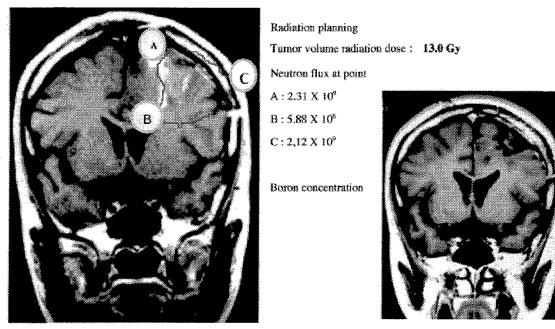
A 41-year-old female with glioblastoma. Planning (left) Aug. 1992 at KUR. Follow up MRI (right) 2 years after BNCT. Radiation dose at target pint "B" was 13Gy.
